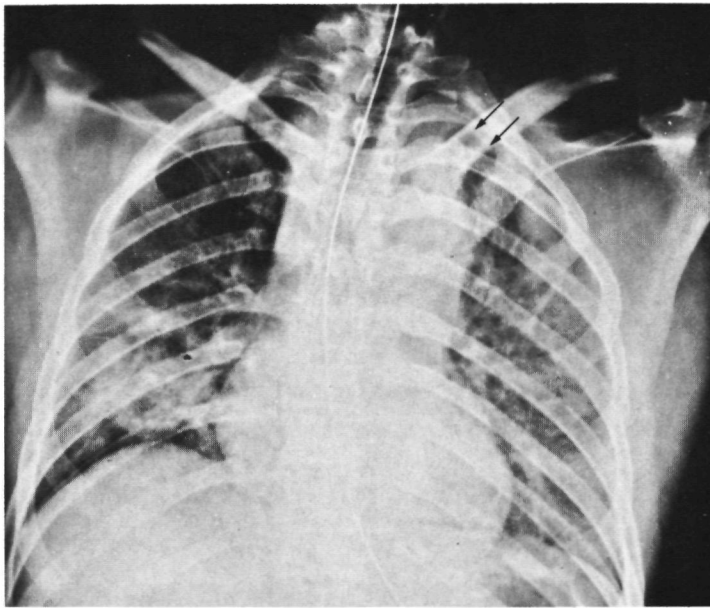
10 Male, 37 years, car-driver, TAR. Uneventful recovery after operation. Chest X-ray: widening of right and left paraspinal lines (black arrows). Widening of paratracheal stripe (white arrow). Note also tracheal displacement and widening of the mediastinal shadow (10 cm) with smooth contours.
